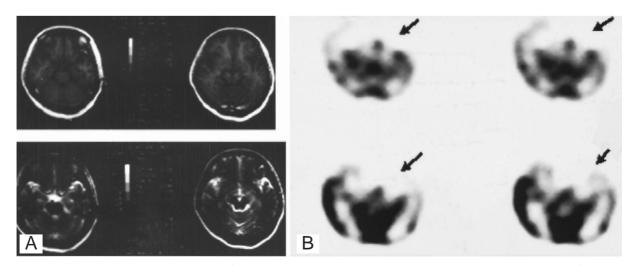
(case no 7) A: MRI (T1W and T2W) of the brain is normal. B: Tc-99m ECD brain SPECT demonstrates hypoperfusion in the left temporal lobe (arrows).
